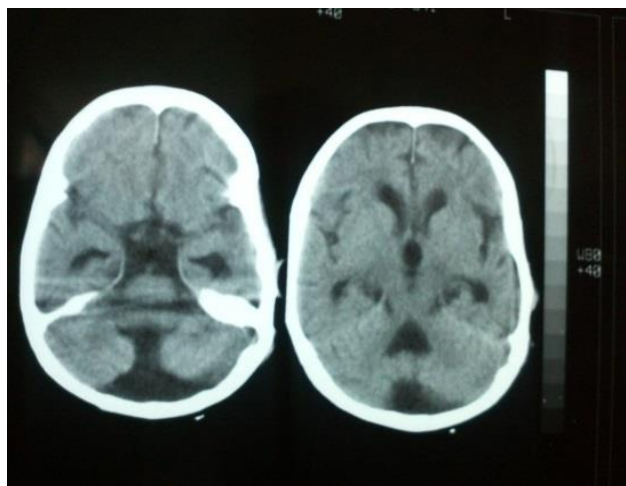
CT image shows posterior fossa which is communicating with the 4th ventricle in the midline and cerebellar vermis is hypoplastic.
